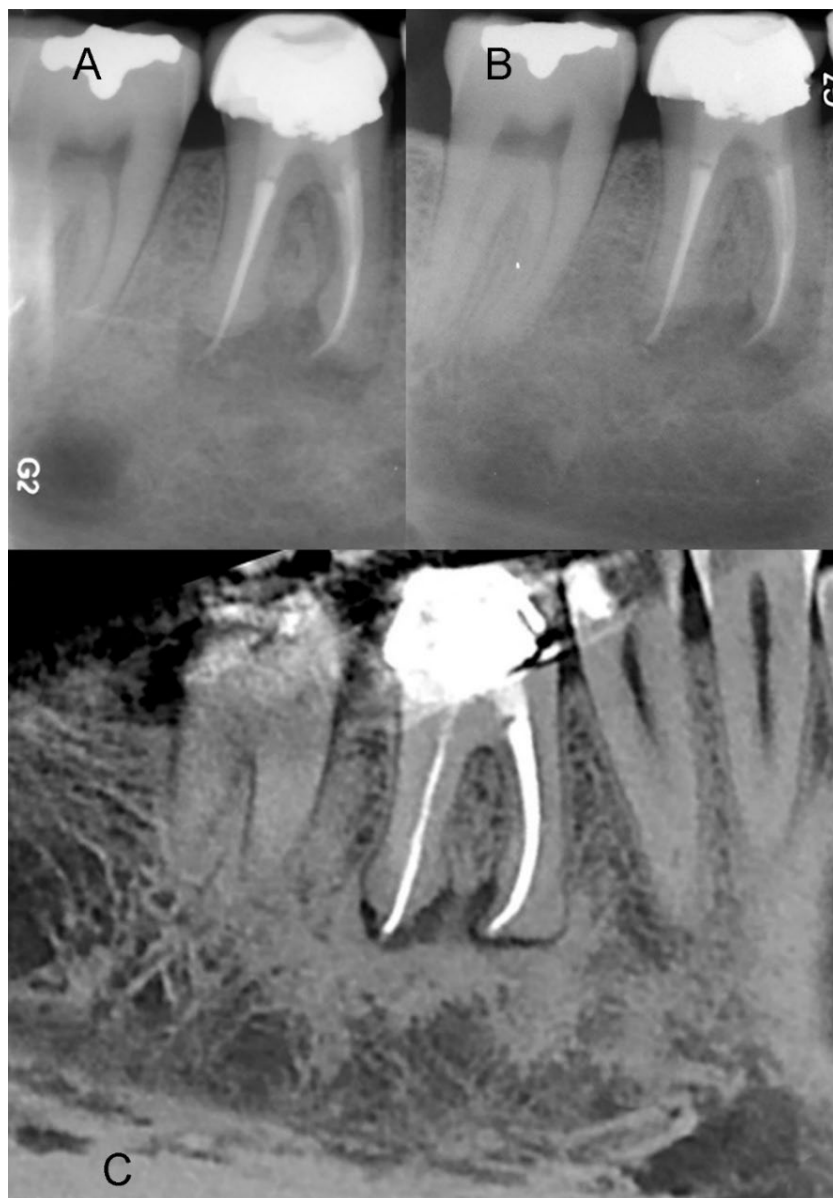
Follow-up radiographic evaluation; A) Six-month follow-up; showing slight resolution of both lesions; the patient reported total disappearance of symptoms; B) One-year follow-up radiograph; displaying almost complete resolution of endodontic lesions, replaced by newly formed bone; C) Cross-sectional views from CBCT at one-year follow-up; confirming the successful resolution of both lesions, with evidence of newly formed bone which filled the previously observed radiolucencies
